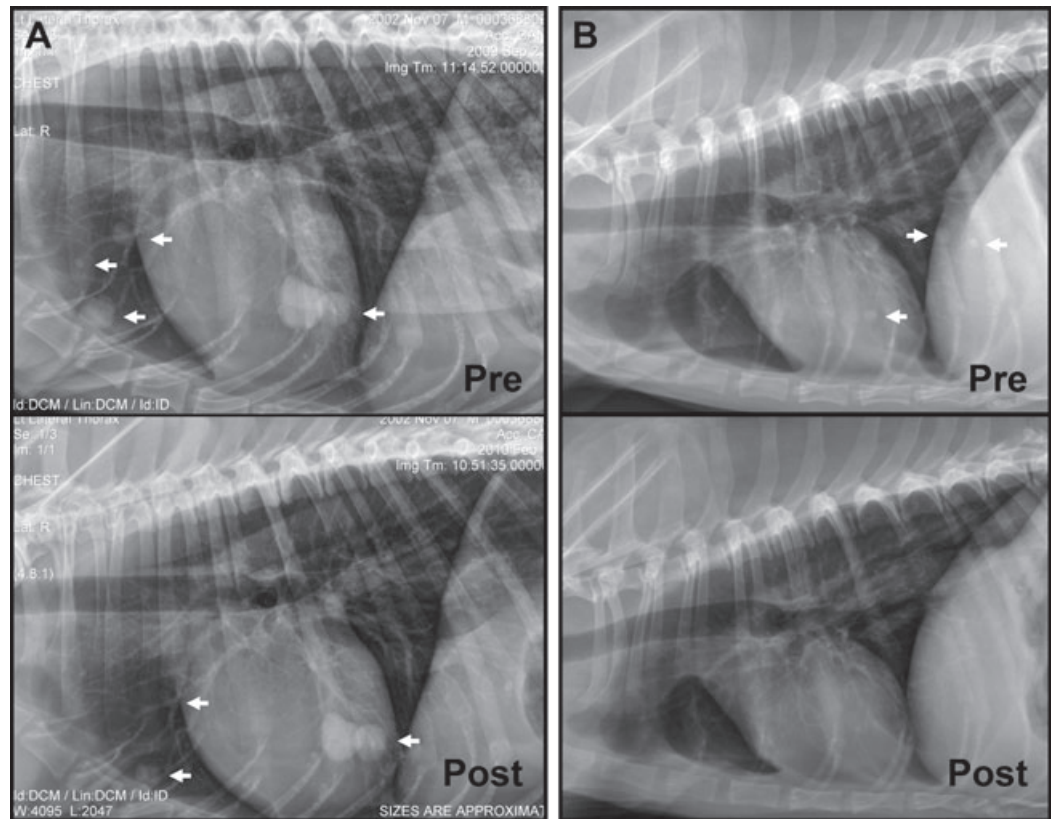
Response of metastatic thyroid carcinoma to toceranib. (A) A 15-year-old intact male Shih Tzu presented with a primary thyroid carcinoma and pulmonary metastasis. Toceranib therapy was initiated resulting in partial regression of the primary tumour (not shown) and complete regression of the pulmonary metastases. Shown are thoracic radiographs before and 4 weeks after beginning toceranib. (B) A 9-year-old male neutered Labrador retriever presented with metastatic thyroid carcinoma in May 2009. He underwent surgical excision of the primary mass and five cycles of chemotherapy with a doxorubicin/cyclophosphamide/5-fluorouracil regimen. He experienced progression of his pulmonary metastases and was placed on toceranib. Shown are his thoracic radiographs before initiating toceranib in September 2009 and 5 months later in February 2010.
